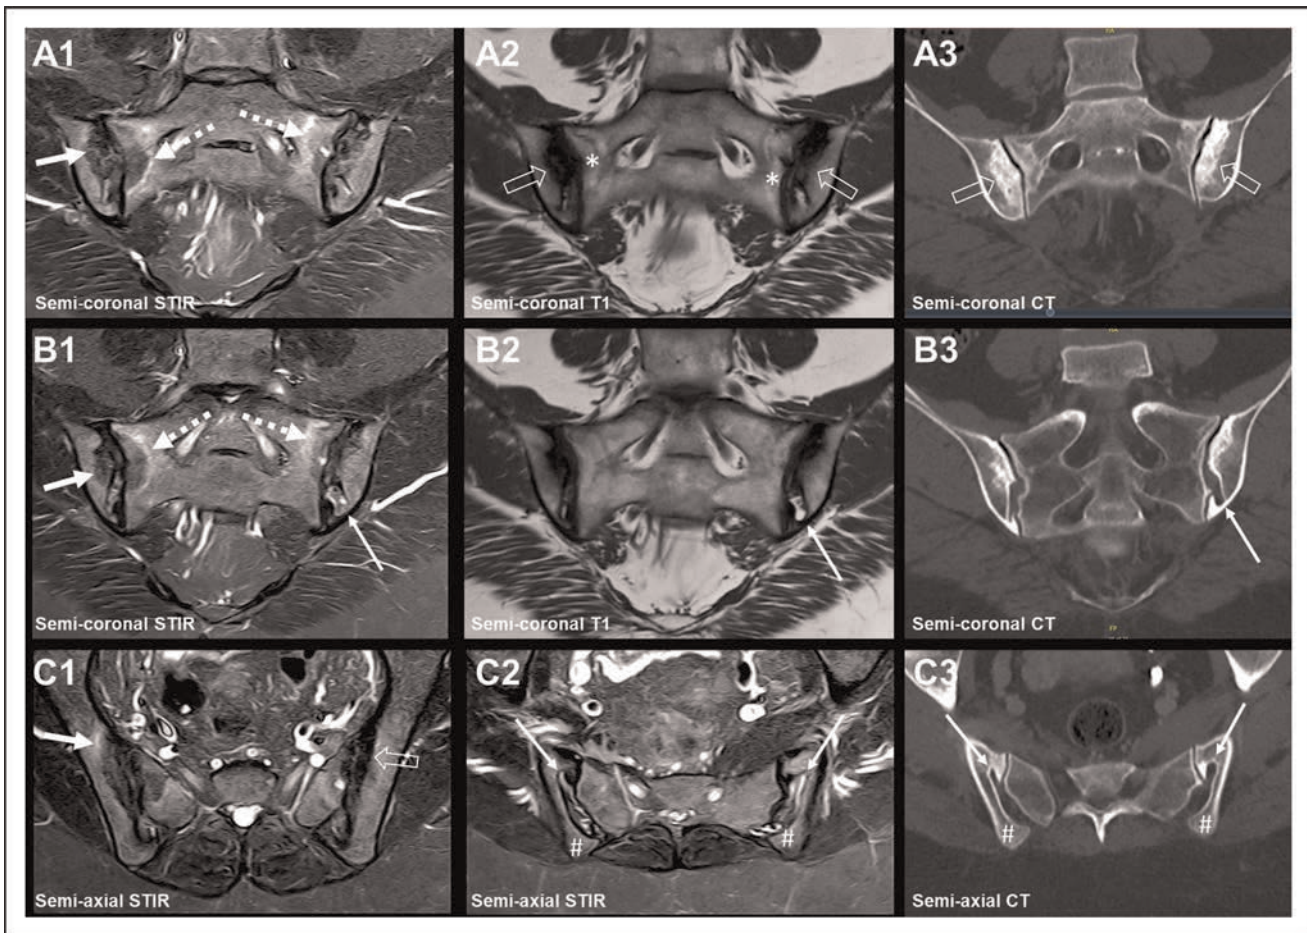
Bipartite and crescent-like iliac bony plate, and osteitis condensans ilii. MRI in a 44-year-old woman with buttock pain after her second pregnancy 2 years previously, but no clinical axial spondyloarthritis suspect changes; normal CRP and HLA-27 negative. Two semi-coronal STIR (a1, b1) and corresponding T1-weighted images (a2, b2) with supplementary semi-axial STIR images at the middle (c1) and lower part of the joints (c2) and CT images in the same slice orientations (a3, b3, c3). A bilateral bipartite variation is seen at the lower posterior part of the joints with fluid filled vessels surrounded by fat in the clefts (long slim arrows on b1, b2, b3, c2, c3), most pronounced on the left side. The semi-axial images show a concave configuration of the iliac bone (# on c2, c3) with relatively congruent bulging of the opposite sacral bone, consistent with crescent-like iliac bony plate, most pronounced on the right side. The osteitis condensans ilii changes consist of manifest bilateral iliac sclerosis anteriorly in the ilium (open arrows on a2, a3) with surrounding BME (arrows on a1, b1, c1) in addition to subchondral fat lesions in the sacrum (asterisks on a2) surrounded by BME (dashed arrows on a1, b1). BME, bone marrow edema; CRP, c-reactive protein; SIJ, sacroiliac joint; STIR, Short Tau Inversion Recovery.
